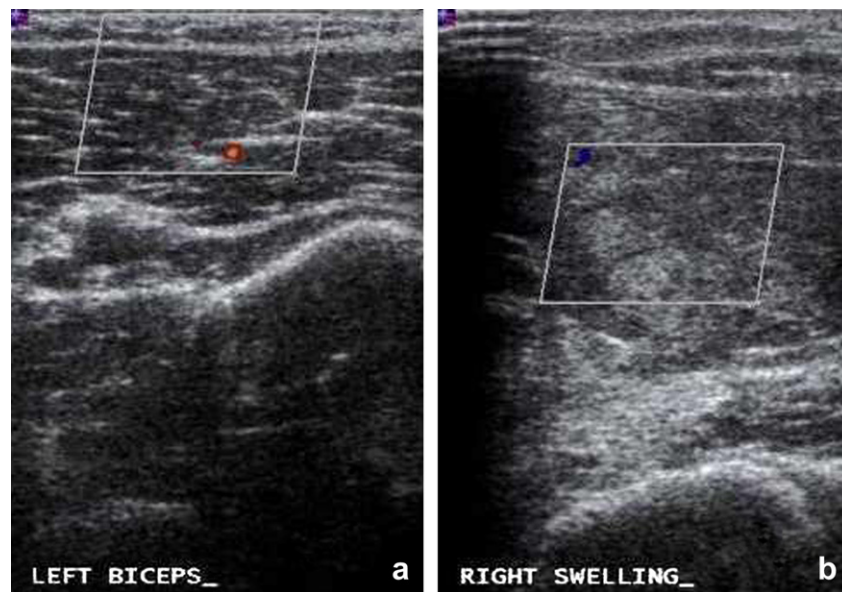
Ultrasound image of the upper arms demonstrating normal flow within the left biceps (a) compared with compromised flow on the right (b).
